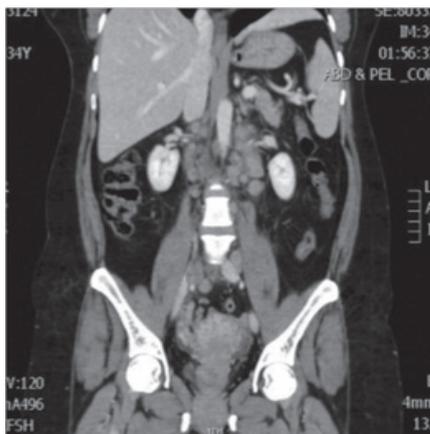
Coronal CT Scan Showing Interval Improvement
